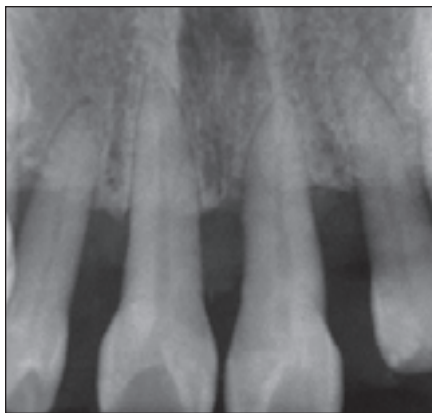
Initial panoramic and periapical radiographs and intraoral view of the incisor relationship.
